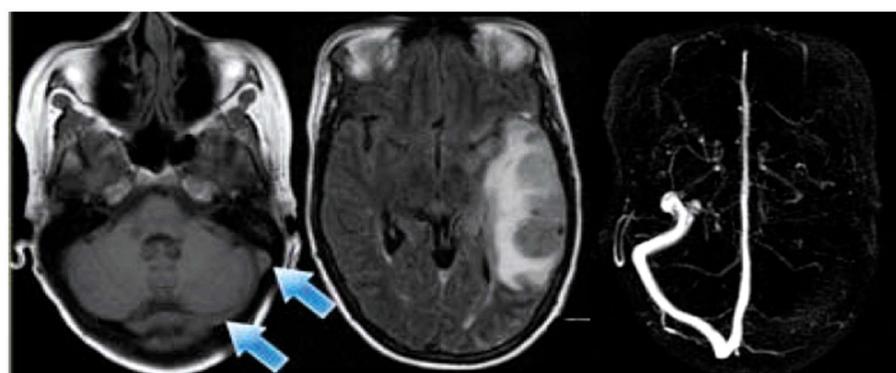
MRI 可左侧横窦内条状等 T1 信号(蓝色箭头),为窦内血栓,左侧横窦存在,合并脑出血
